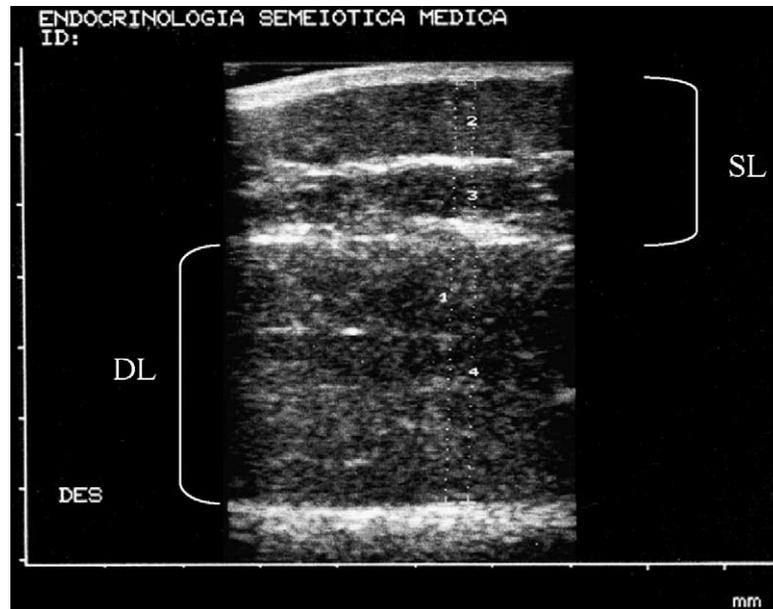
Ultrasound analysis of thigh fat: two separate layers are evident with dense separating membranes: superficial layer (SL) and the deep layer (DL).
